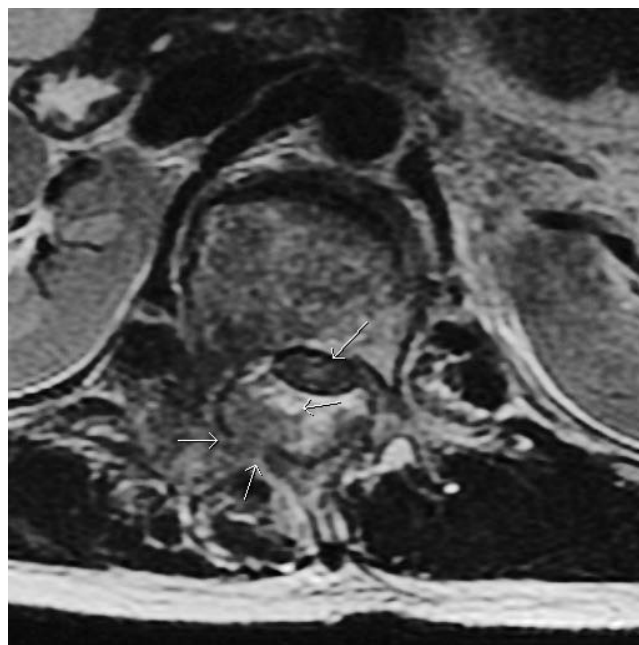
Axial FRFSE (fast relaxation fast spin echo) T2-weighted magnetic resonance image demonstrates central cord edema, posterolateral epidural hematoma, and a fracture involving the lamina of L1. The most anterior arrow demonstrates the spinal cord. The remaining (more inferiorly oriented) arrows outline the laminar fracture and hematoma.
